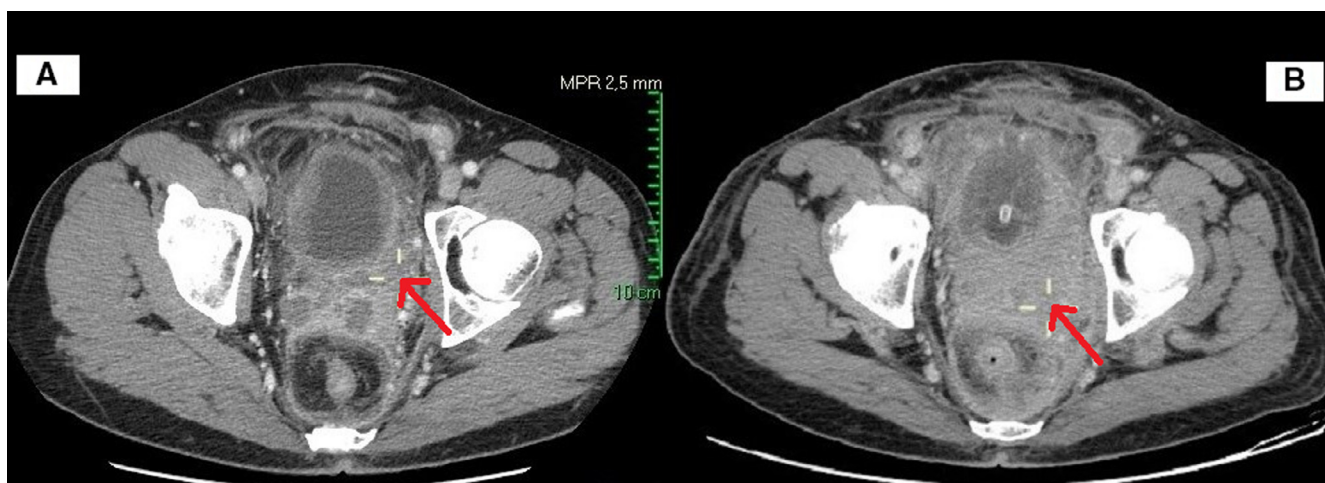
Abdominal CT in axial plane performed 10 days after the urine leakage (B) compared to the CT performed after stent placement (A) shows dimensional increase of the high density fluid located in pelvis, pointed by the arrows.
